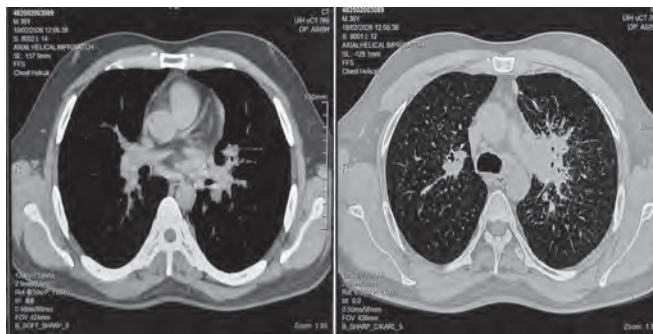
HRCT thorax showing bilateral pulmonary nodules, ground-glass opacities and enlarged mediastinal lymph nodes
